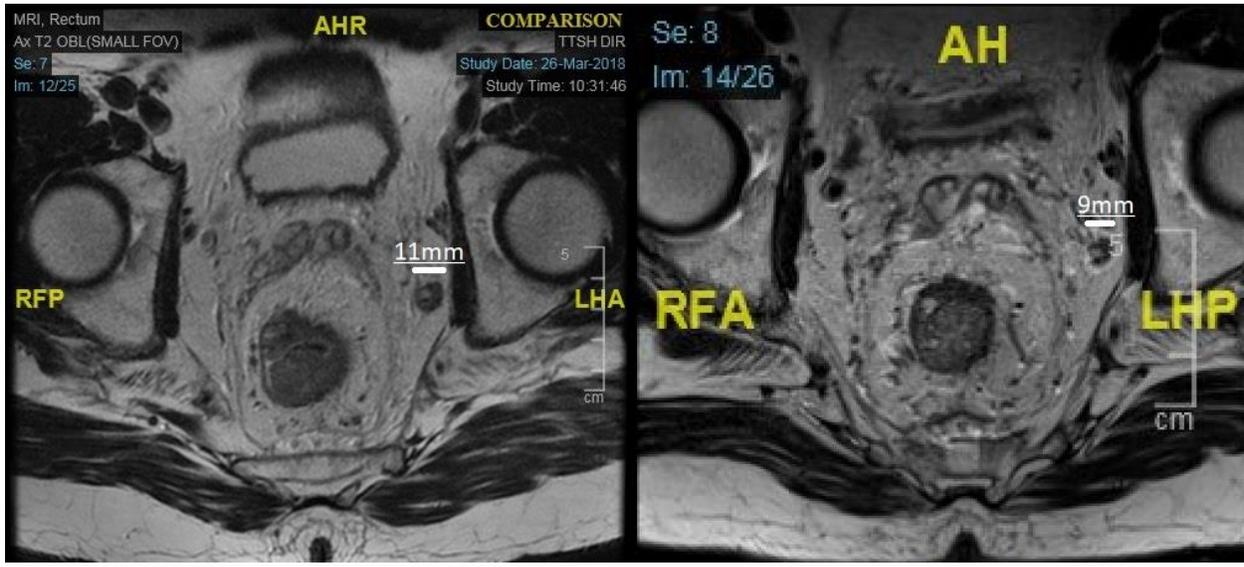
MRI Rectum showing an enlarged, metastatic, left internal iliac node before (left, 11mm) and after (right, 9mm) neoadjuvant chemoradiation.
